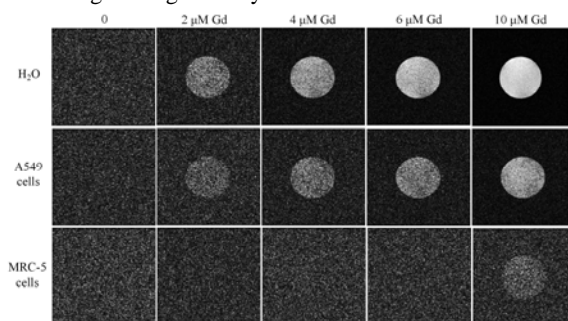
T<sub>1</sub>-weighted MR images of GQDs-Gd in water, A549 cells and MRC-5 cells with different Gd concentration.
